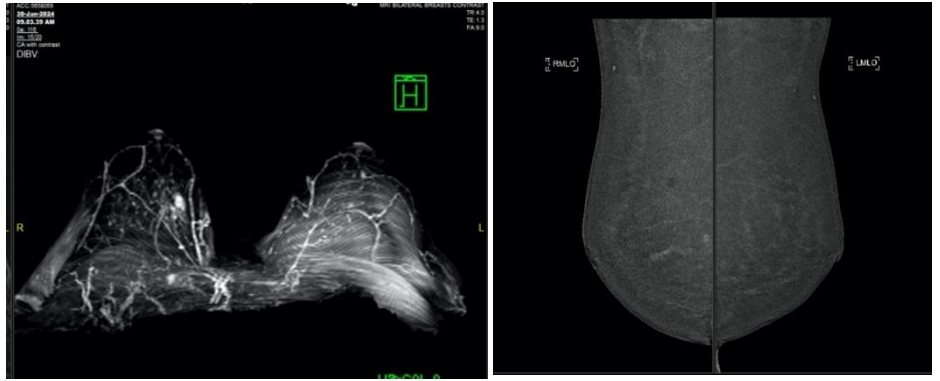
Recombined CEDM images showing enhancement at right upper inner quadrant (DCIS) and left upper outer quadrant (benign) . CE-MRI showed left UOQ enhancing breast lesion and right breast upper inner segmental heterogenous NME.
